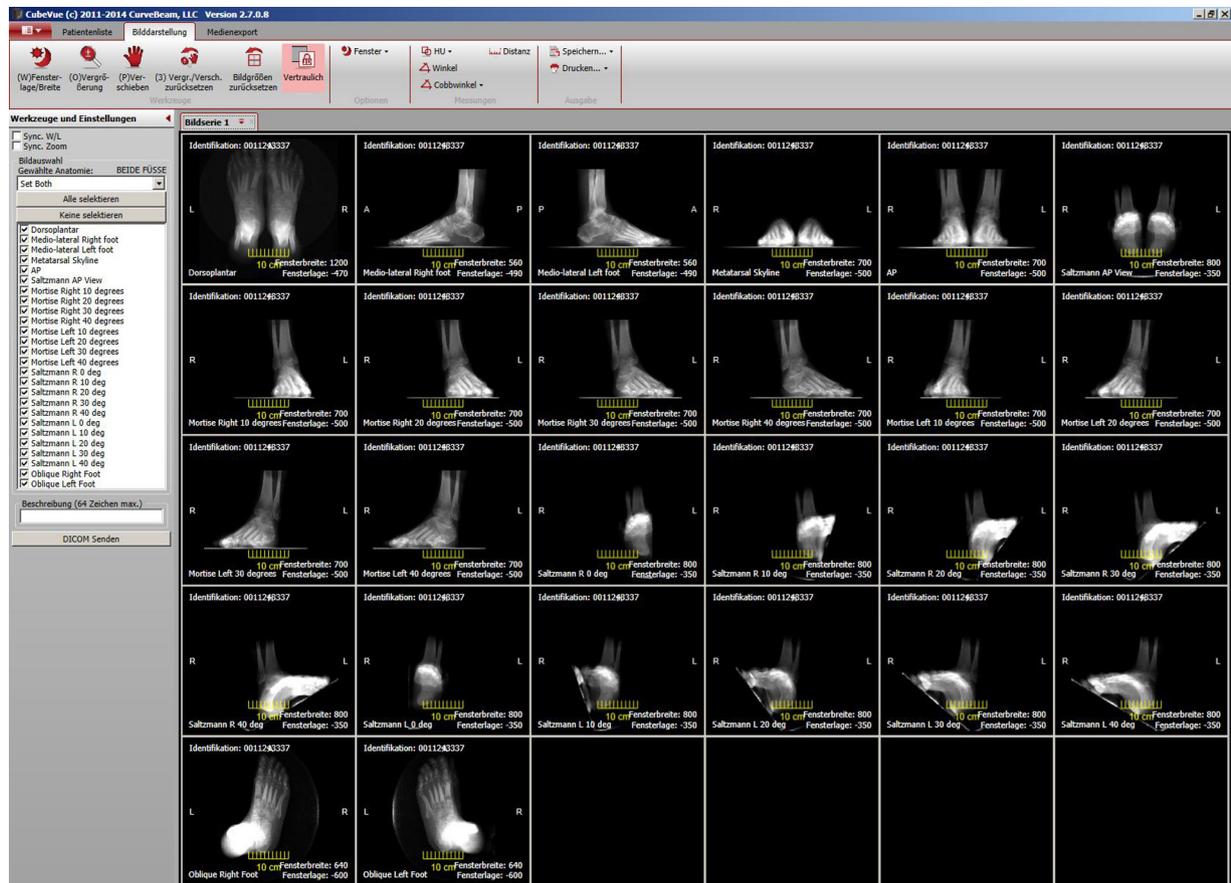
Generation of virtual standard radiographs from 3D-pedCAT-data. First row from left to right, feet bilateral dorsoplantar, right foot lateral, left foot lateral, metatarsal skyline view bilateral, ankle ap bilateral, Saltzman view bilateral. Second row from left to right, Mortise right 10° internal rotation, Mortise right 20° internal rotation, Mortise right 30° internal rotation, Mortise right 40° internal rotation, Mortise left 10° internal rotation, Mortise left 20° internal rotation. Third row from left to right, Mortise left 30° internal rotation, Mortise left 40° internal rotation, Saltzman right 0° internal rotation, Saltzman right 10° internal rotation, Saltzman right 20° internal rotation, Saltzman right 30° internal rotation, Saltzman left 0° internal rotation, Saltzman left 10° internal rotation, Saltzman left 20° internal rotation, Saltzman left 30° internal rotation, Saltzman left 40° internal rotation. Fifth row from left to right, foot right oblique, foot left oblique. Other images can be defined as desired. The images can be automatically exported to the local PACS system.
